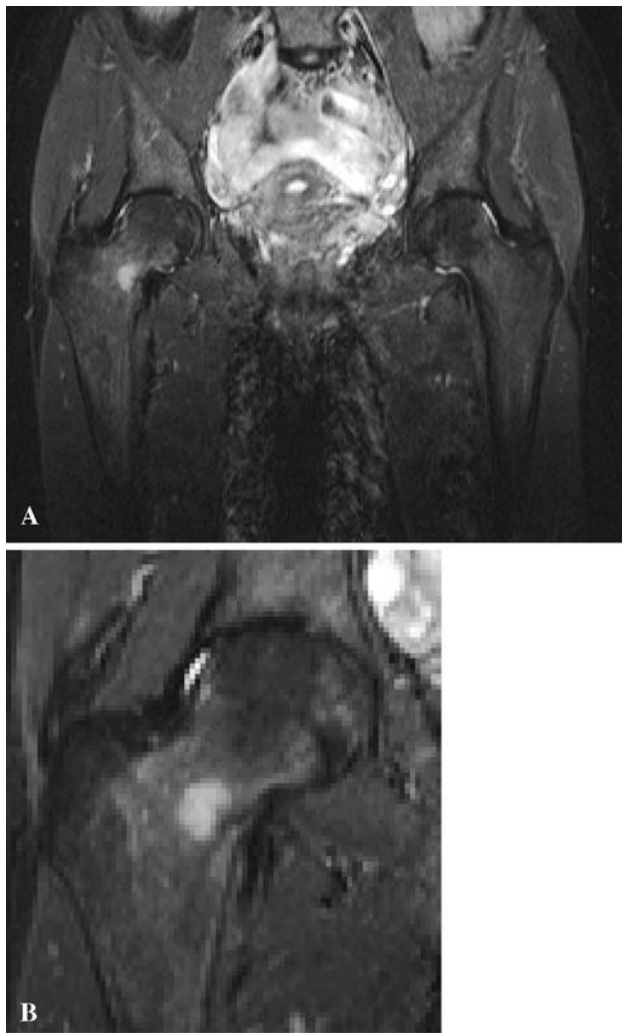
B (A) A T2-weighted coronal MR image of the pelvis shows no increased signal in the left hip but an area of increased signal in the base of the right femoral neck. (B) An enlarged T2-weighted MR image of the left hip shows a linear low-signal fracture extending to the cortical margin along the compression side of the femoral neck with surrounding T2 hyperintense edema.
